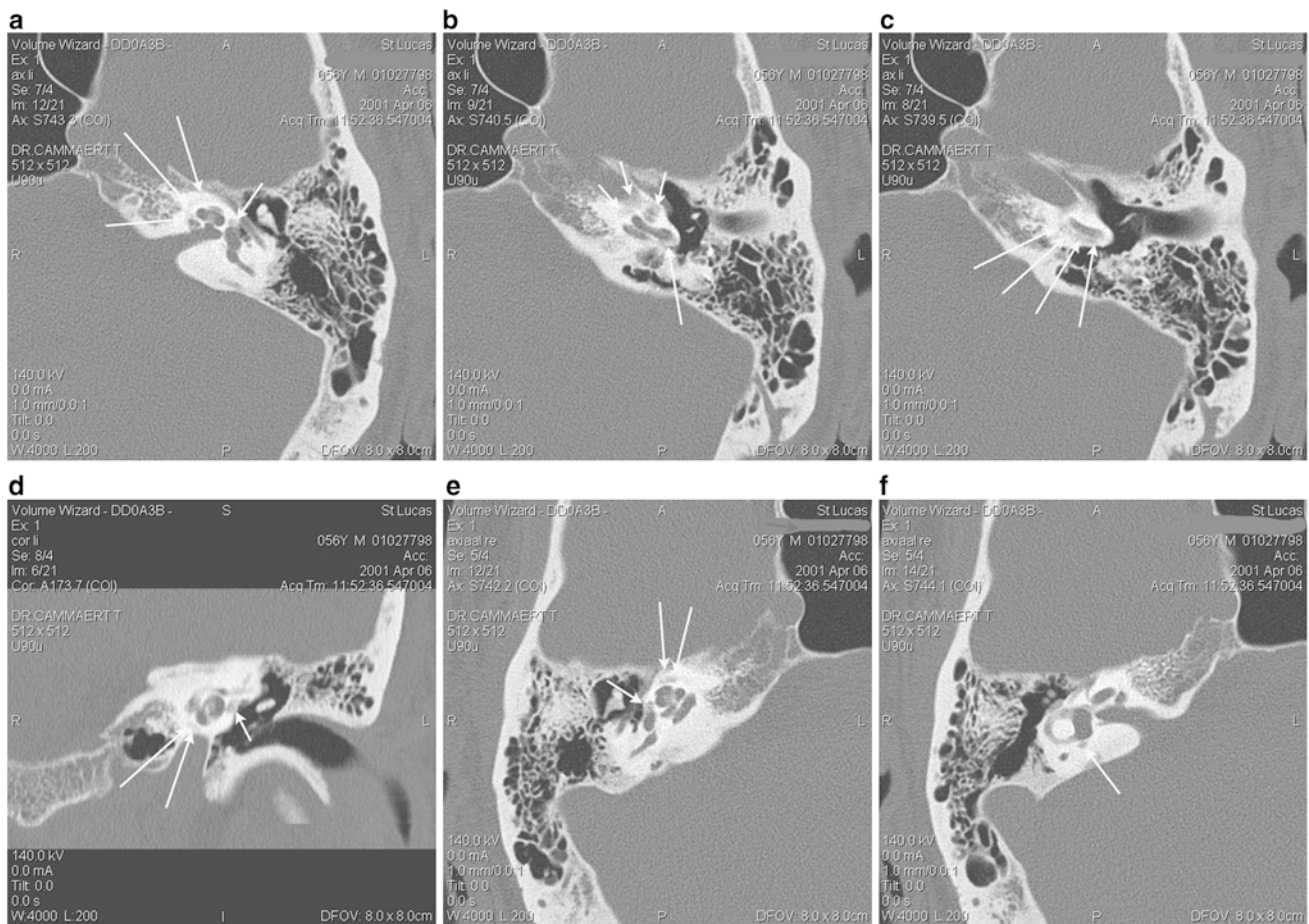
Multiple CT images are shown from a patient with bilateral fenestral and retrofenestral otosclerosis. On the most cranial axial image on the left side (a) lucencies of otosclerotic origin are seen around the cochlea (*large arrows*) and anterior to the oval window (*small arrow*). On the image below (b) cochlear otosclerosis is seen medial to the apical and middle cochlear turns (*small arrows*), but also around the basal cochlear turn, and in the round window region (*large arrows*). On the slice more caudally (c) more otosclerotic foci are
